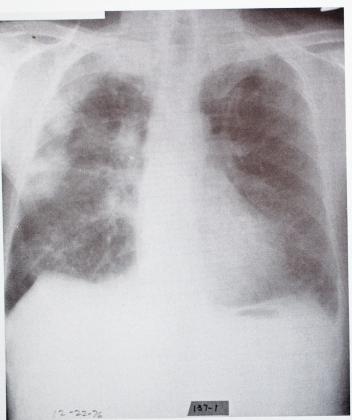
A radiograph of a patient with chronic eosinophilic pneumonia shows bilateral, upper lobe, peripheral, fluffy infiltrates, which are most prominent on the right side. The interstitial markings are increased.
